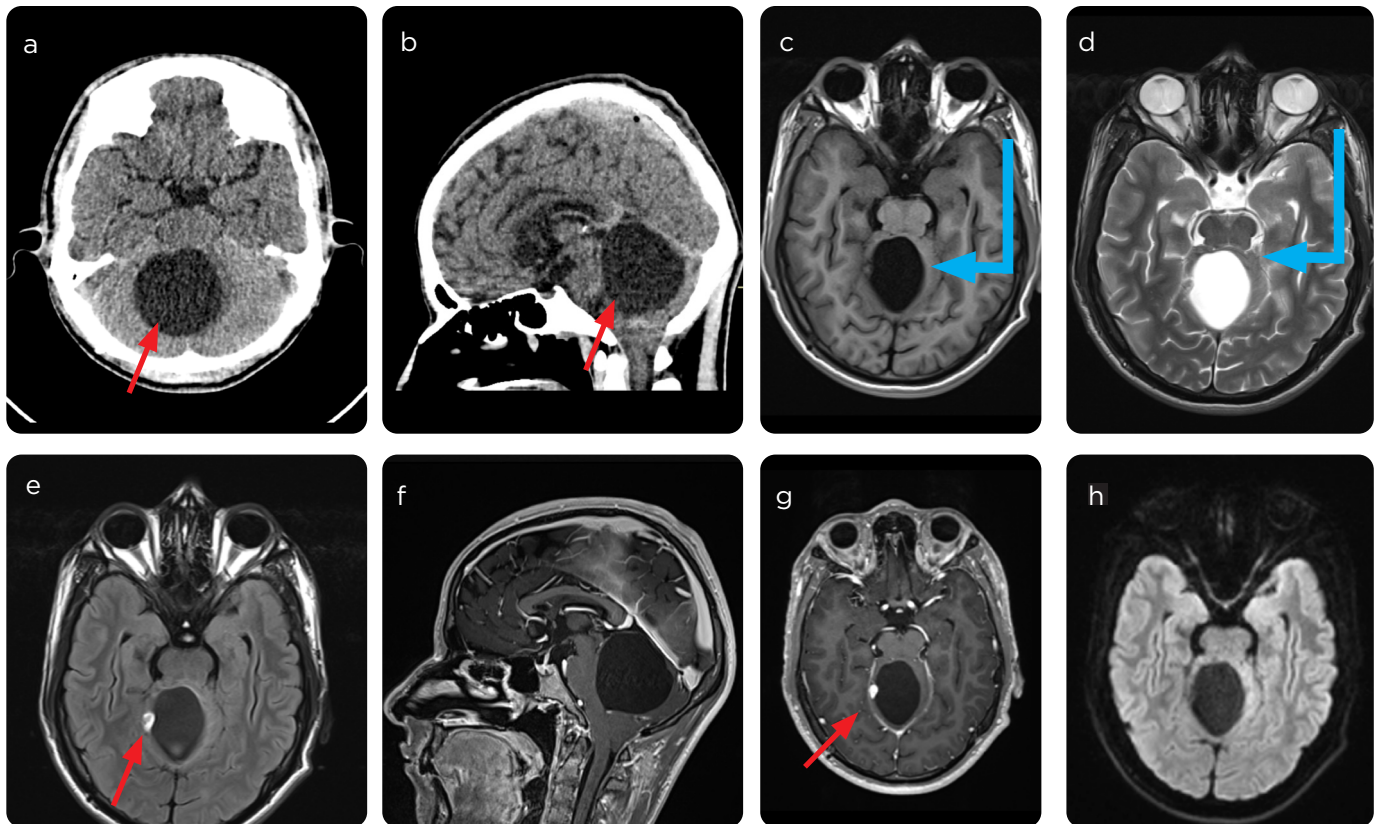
Hemangioblastoma. a) Axial and b) sagittal CT: lesion of CSF-like density, well delimited from the cerebellar vermis. c) MR sequences with T1 information: low signal. d) Spin-echo sequences and e) FLAIR with T2 information, high signal with mural nodule of intermediate signal similar to the gray matter. f and g) With contrast medium: homogeneous enhancement. h) Diffusion sequence: no restriction to water diffusion.
